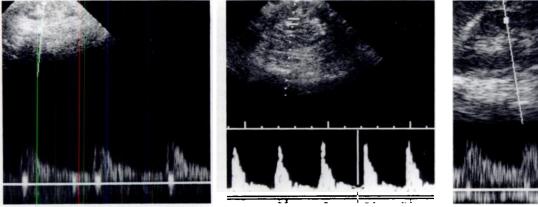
Renal Doppler sonogram of patient with acute tubular necrosis. Patient had a rapid rise in creatinine level from 1.4 to 3.1 mg/dl in 2 weeks. Standard real-time sonography of kidneys was normal. Doppler signal from intrarenal artery shows reduced end diastolic flow resulting in an elevated resistive index of 0.78. Renal biopsy was consistent with acute tubular necrosis. Fig. 2.—Renal Doppler sonogram of patient with vasculopathy. Creatinine level became elevated after a cardiac transplant. Standard realtime sonography was normal. Doppler signal obtained from intrarenal artery shows a significant reduction in end diastolic flow compared with peak systolic flow, resulting in an elevated resistive index of 0.83. Biopsy revealed changes consistent with cyclosporine vasculopathy.
